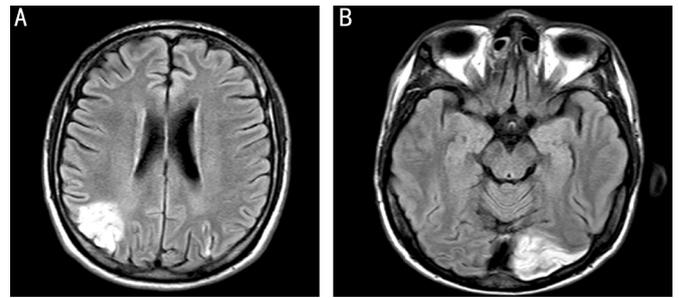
MRI scan of a 38-year-old male patient who underwent bilateral LT. Images show evidence of several hypodense areas with an effacement of the fissures at bilateral occipitoparietal level.
